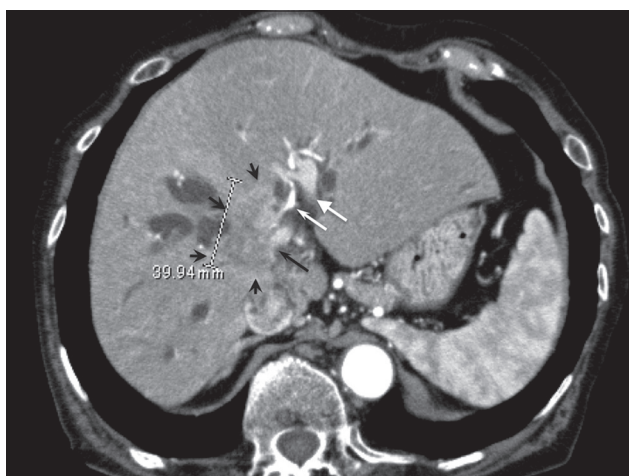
Computed tomography showing a bulky low-density mass at the hepatic hilum predominantly in the right lobe (arrowheads), involving the right portal vein (black arrow), and attached to the left hepatic artery (white arrow) and nearly intact left portal vein
